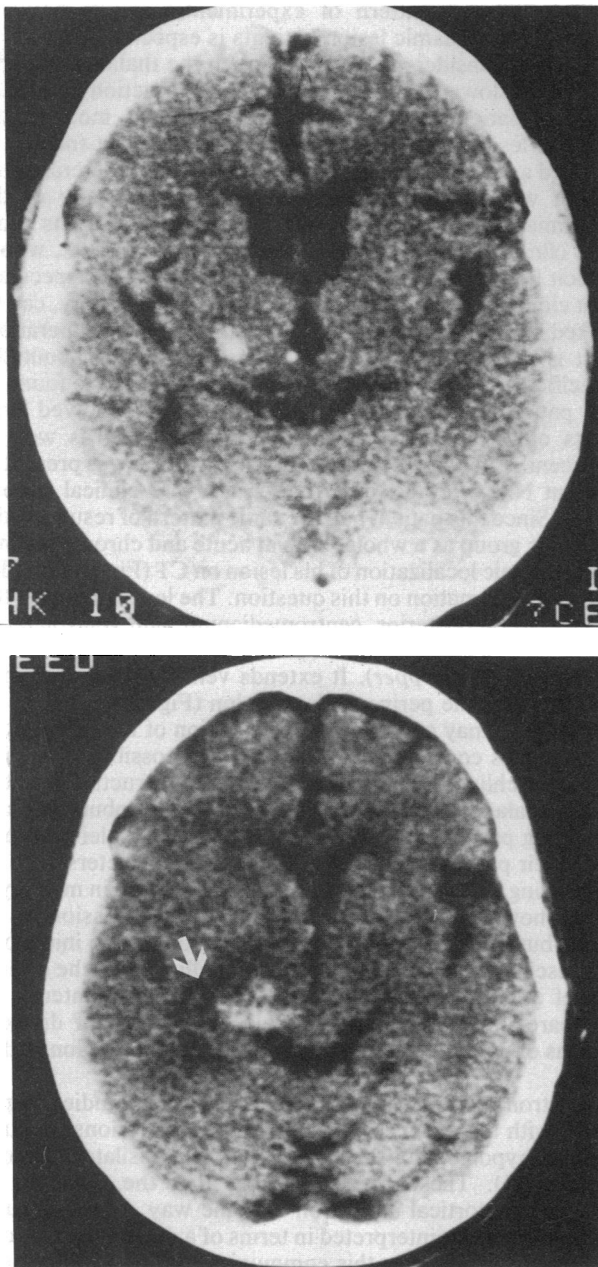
CT scan from patient NA at the time of his stroke. (Upper) There is a small hematoma in the right thalamus centered in the ventrolateral nucleus and involving nuclei lateral posterior and centromedianum. (Lower) The hematoma extends into the posterior limb of the internal capsule and ventral to the thalamus into the area of the zona incerta and into the perigeniculate region (arrow).
